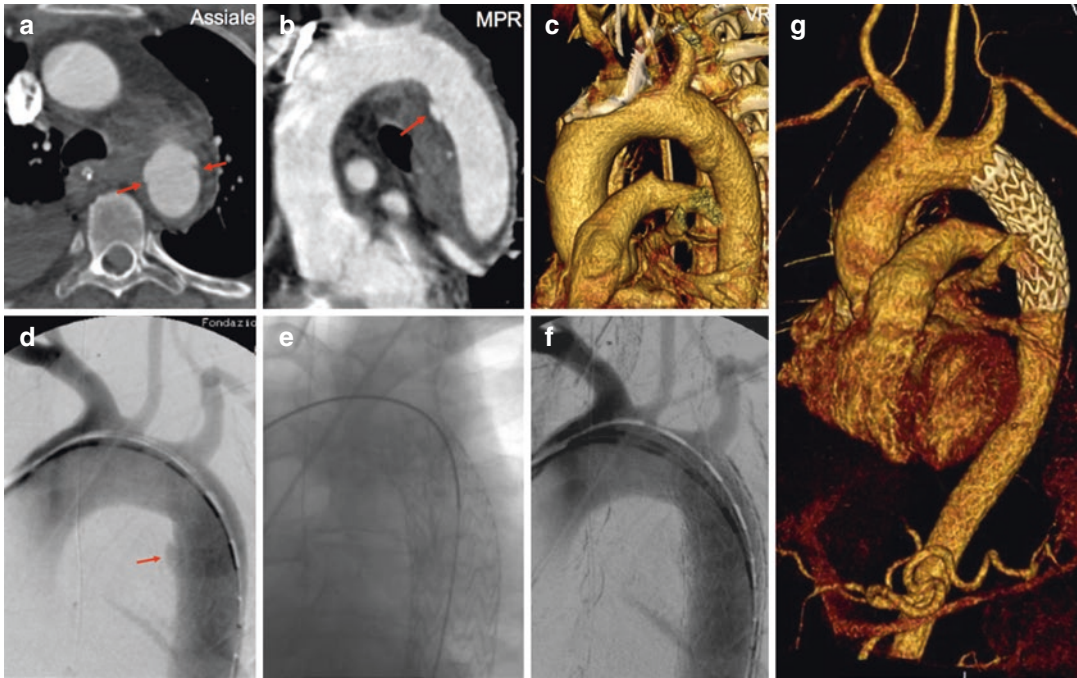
(a–c) CT-angiography showing intimal tear at the aortic isthmus (*arrows*); (d) DSA confirms the presence of an intimal tear (*arrow*); (e, f) placement of the stent
